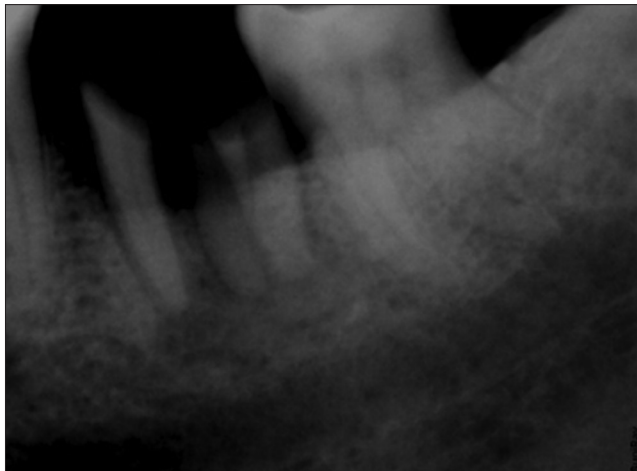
Pre-operative periapical radiograph of tooth #38
